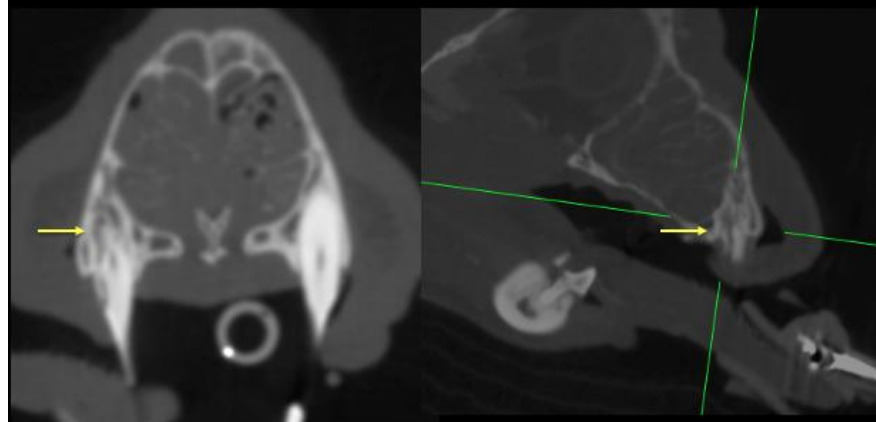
Periapical root resorption
